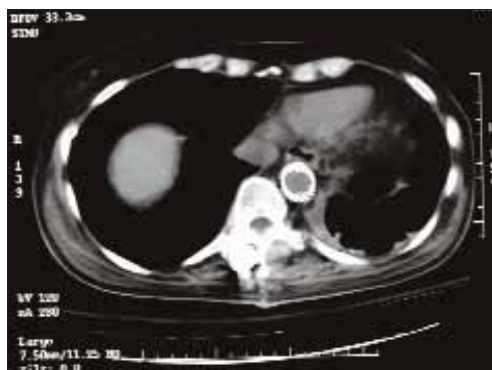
CT scan demonstrates stability of the spine and acceptable position of the stents without evidence of a leak.
